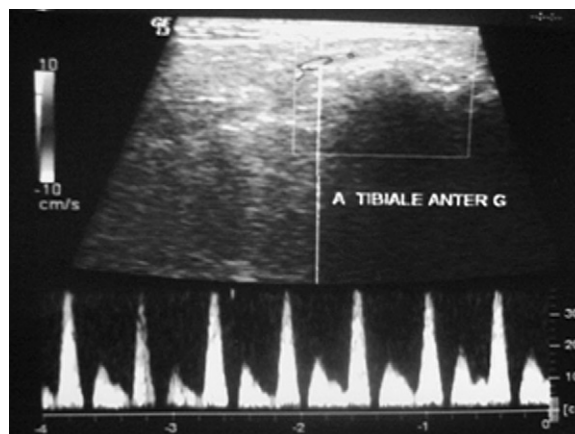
Continuous Doppler ultrasonography shows acceleration of right anterior tibial flow, without significant stenosis.
